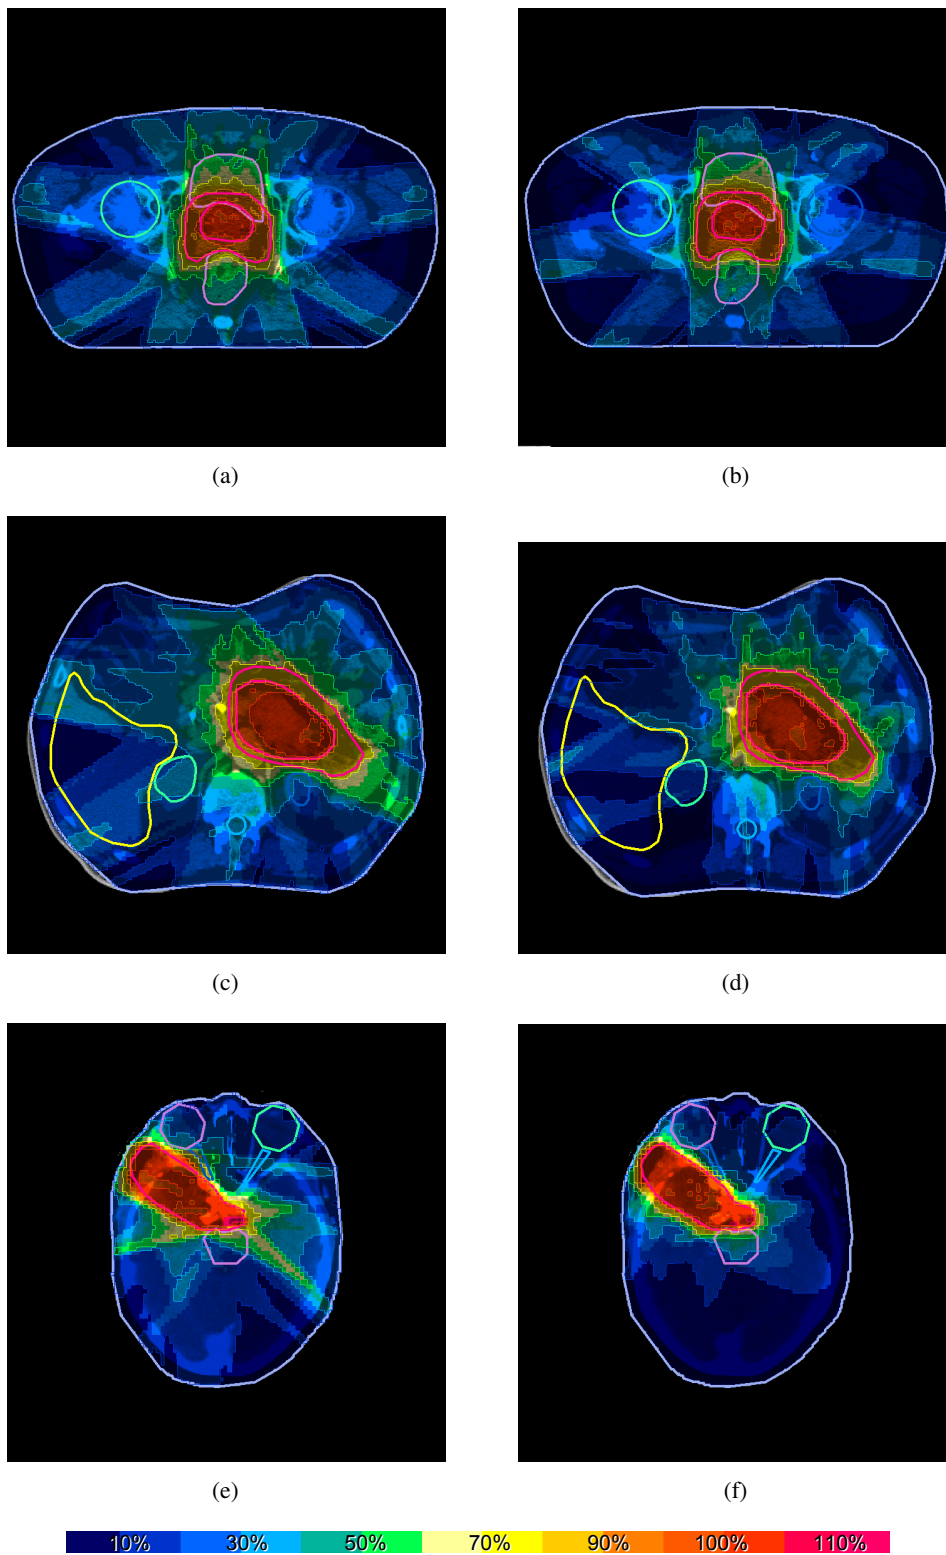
Dose distribution on a selected transversal CT slice for (a) & (b) Prostate lesion II, (c) & (d) abdominal lesion I, and (e) & (f) intracranial lesion III. The dose distributions (a), (c), and (e) are computed with nine equi-spaced coplanar beams, the dose distributions (b), (d), and (f) are computed with seven optimized non-coplanar beams. 100% corresponds to the prescribed target dose.
